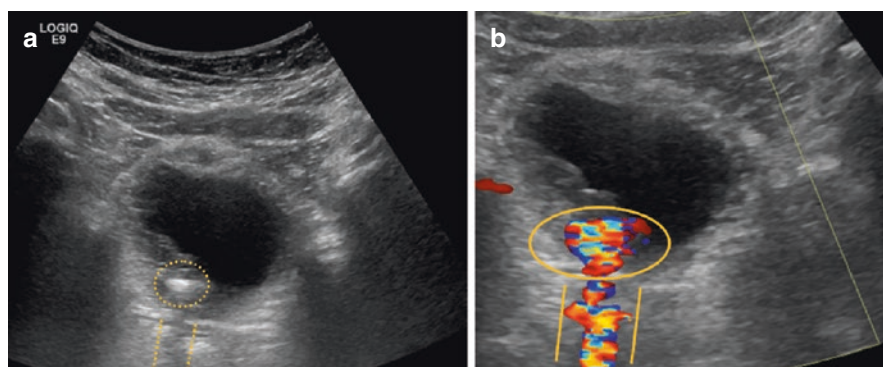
Sonographic findings of a distal ureteral calculus at the ureterovesical junction. (a) The echogenic focus (dashed circle) causes posterior acoustic shadowing (dashed lines). (b) Twinkle artifact (solid ellipse) is seen within the calculus, while an associated color comet tail (solid lines) is present deep to the calculus
